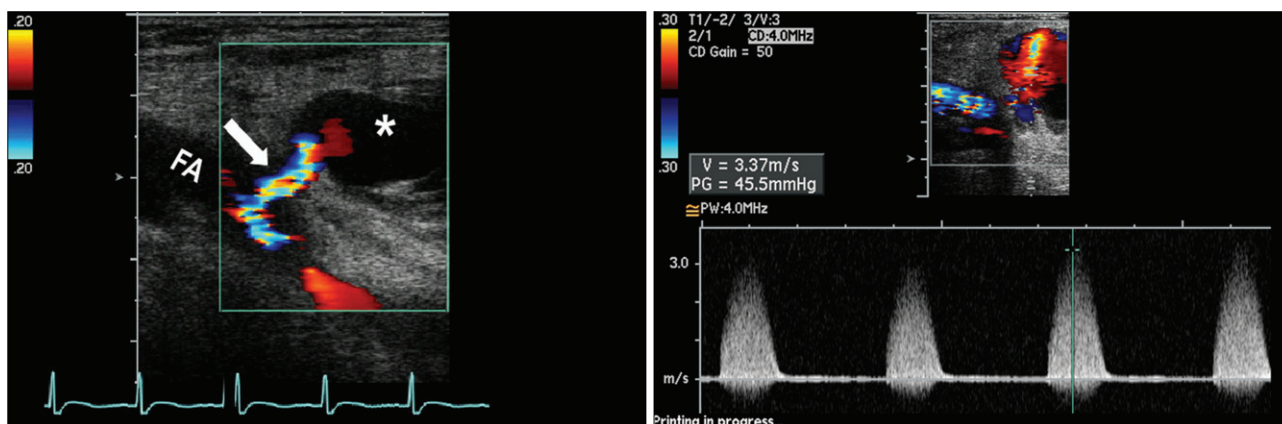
Duplex ultrasound image showed 3.2 × 1.5 cm sized pseudoaneurysm (*) and high velocity flow through a neck (arrow) from femoral artery (FA).
